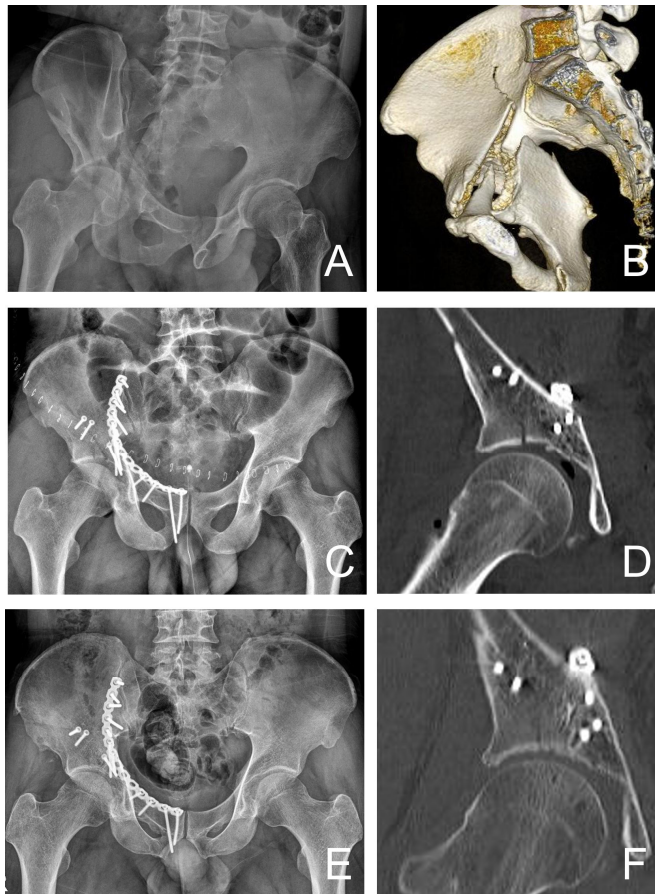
Case presentation I. A 41-year-old man underwent indirect fixation with suprapectineal plate. (A) Radiograph shows both column fracture with 30 mm displacement. (B) Three-Dimensional CT scan shows both column fracture with quadrilateral plate displacement. (C) Indirect fixation with suprapectineal plate is done. (D) CT scan shows congruent reduction. (E) Radiograph obtained 41 months after surgery shows union at the fracture site and good grade with Matta's outcome grading. (F) CT scan also shows mild joint space narrowing, but no sign of osteophyte, subchondral sclerosis and femoral head collapse. CT: computed tomography.
